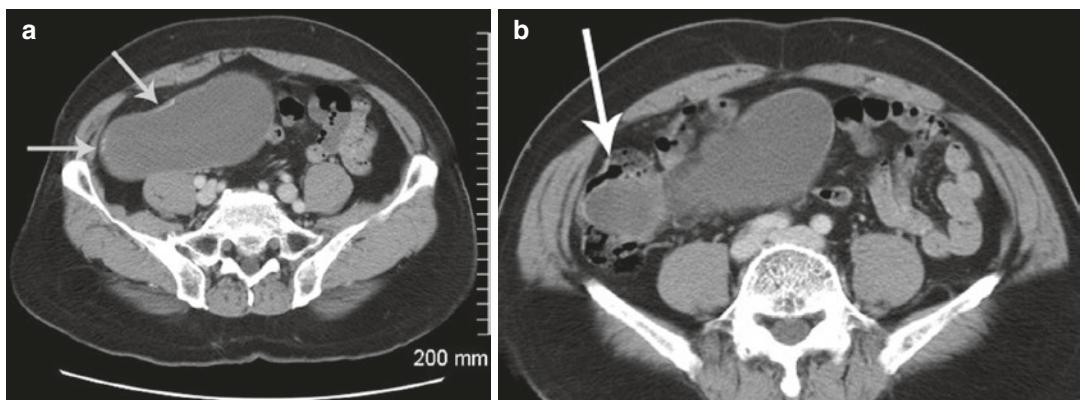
(a) Axial CT of a 47-year-old woman with right lower quadrant pain showing a long tubular structure measuring 6.6×2.3 cm in the right lower quadrant without any surrounding inflammatory changes (arrows). (b)
